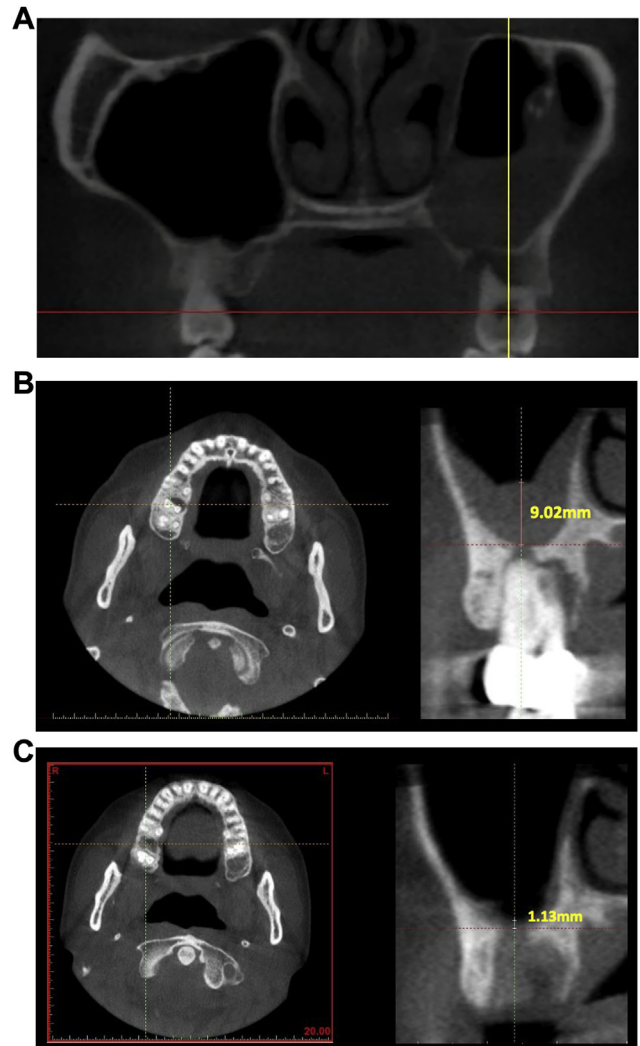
Representative images of cross-sectional cone-beam computed tomography (CBCT) scans from patients with thickened SMT for a single-tooth implant reconstruction in the posterior maxilla pre- and post-extraction. (A) Pre-extraction maxillary sinus with odontogenic infection, showing thickened SMT; (B) Pre-extraction of maxillary second molar for root fracture. Left: Maxillary second molar. Right: Sinus floor perforation and thickened sinus membrane (SMT = 9.02 mm); (C) 4 months post-extraction of maxillary second molar for root fracture. Left: Maxillary second molar area. Right: Subsided sinus membrane (SMT = 1.13 mm).
